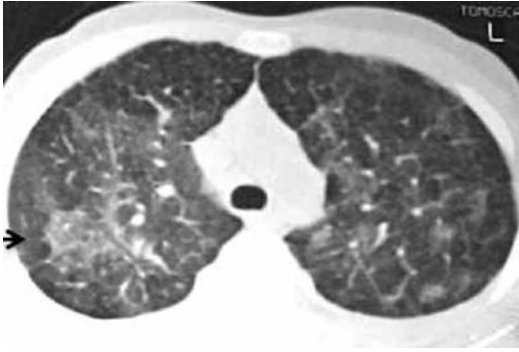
CT scanning of idiopathic pulmonary hemosiderosis (IPH) in a 7-year-old boy with an active hemorrhage, showing cottony, bilateral shapes and a frosted glass effect in the right lung area (arrow)
